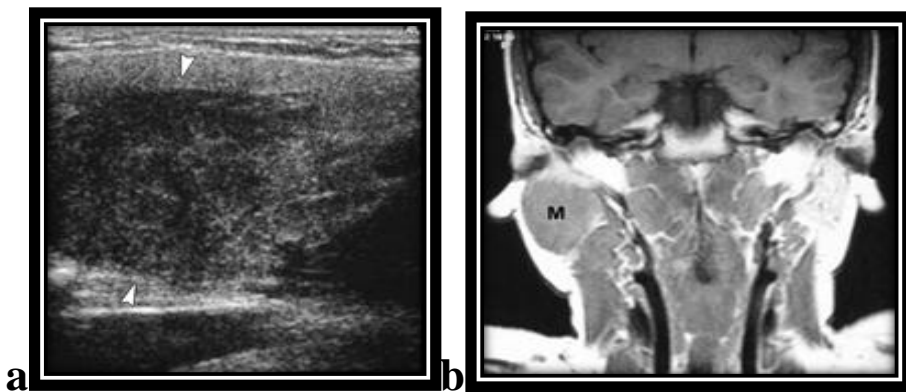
NHL in a 10-year-old girl. (a) US scan of the right parotid gland shows infiltration, which appears as an ill-defined, non homogeneous hypoechoic area (arrowheads). (b) Coronal T1-weighted MR image shows that the infiltrated gland (M) is isointense relative to the neck muscles (*Toma et al., 2007*).
